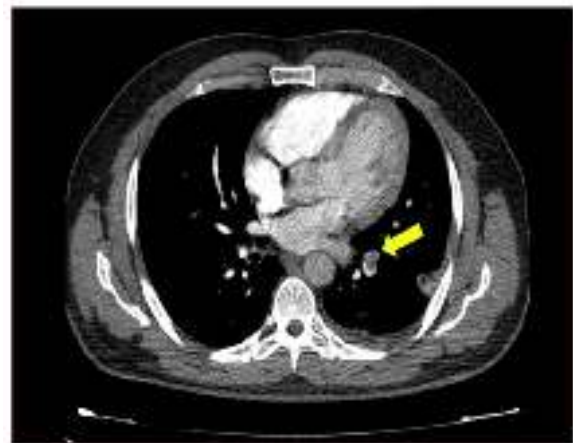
The CT angiography revealed filling defect in the left inferior lobar branch of the pulmonary artery
